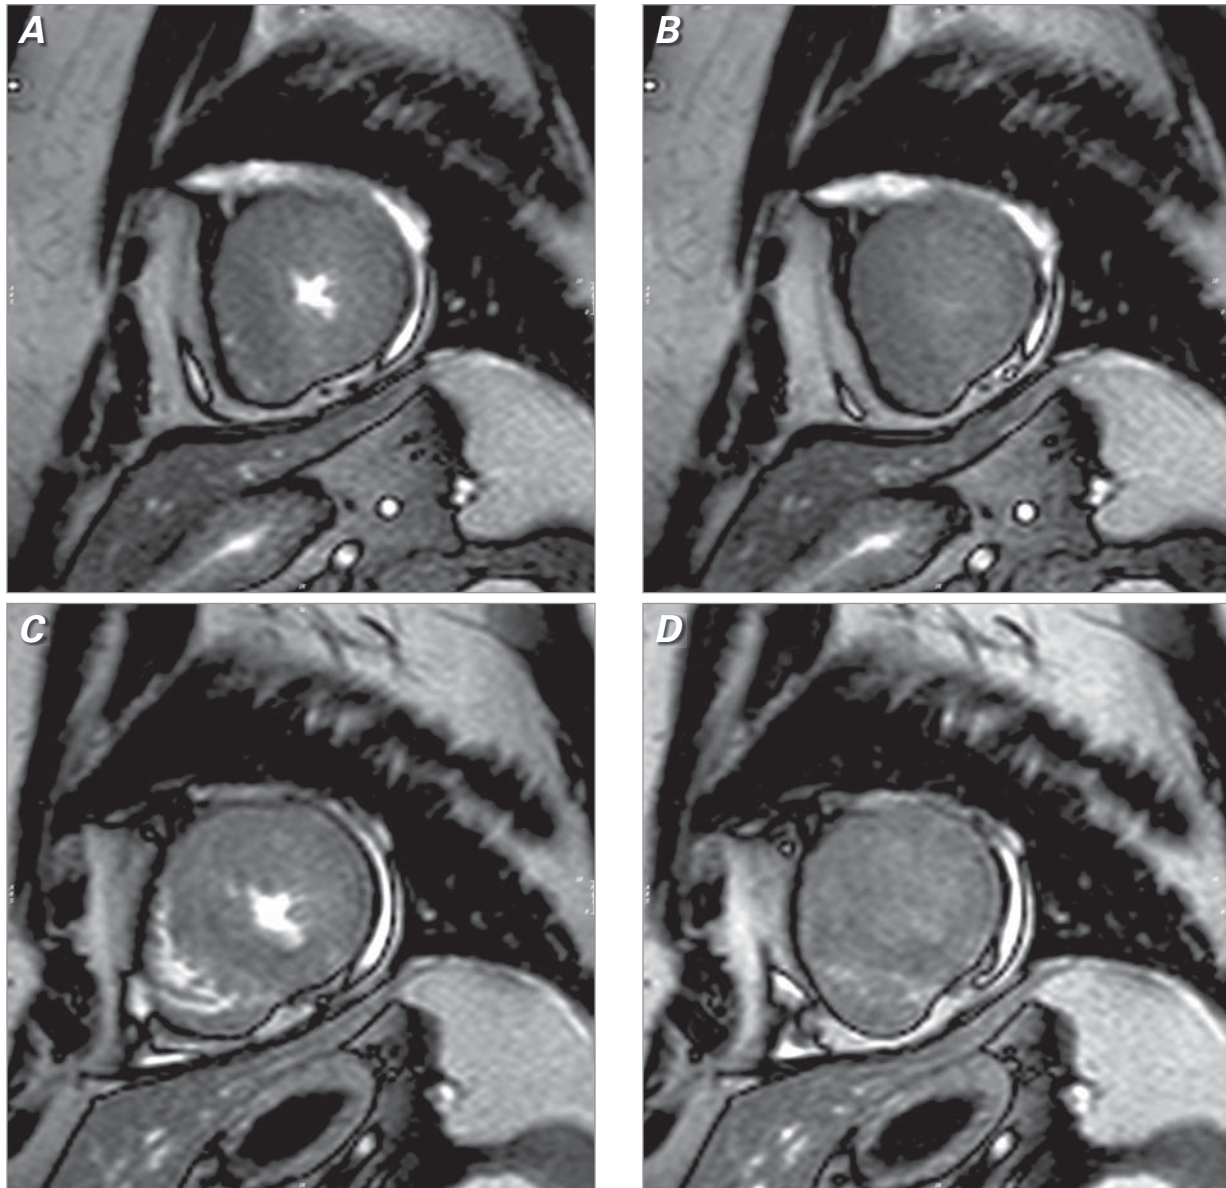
Magnetic resonance imaging frames (cross-sectional views at the mid-cavity obstructive ring). A) Preoperative diastolic, B) systolic, and C) postoperative diastolic, and D) systolic images show that the mid-ventricular ring opening was essentially obliterated in both preoperative and postoperative systolic times.
